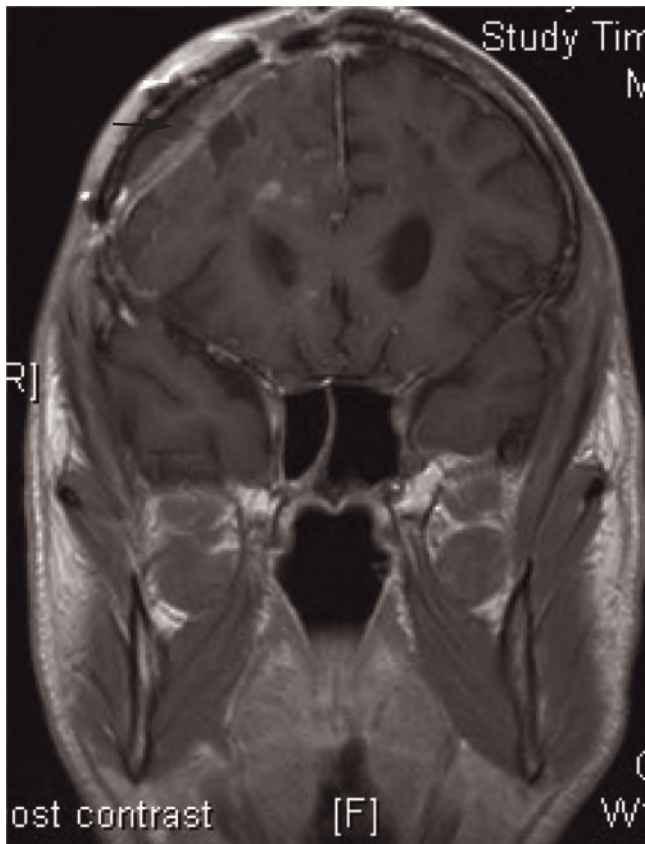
Large subdural empyema following previous craniotomy for grade II glioma (MRI T1W).
